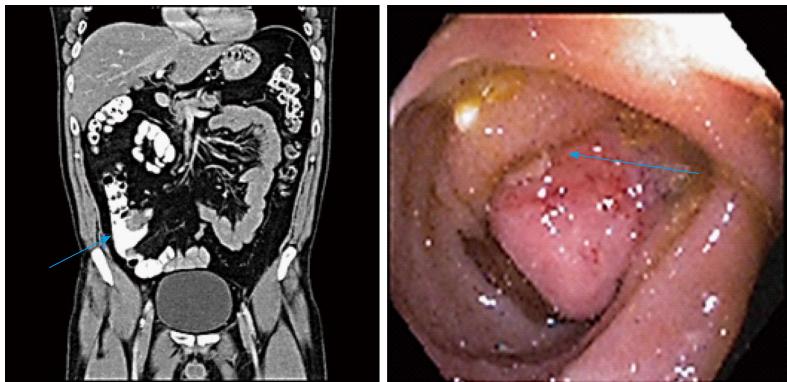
Terminal ileal mass intussusception into the cecum. Computed tomography (CT) scan shows the mass, colonoscopy view confirms the CT finding. Both depicted with a blue arrow.
